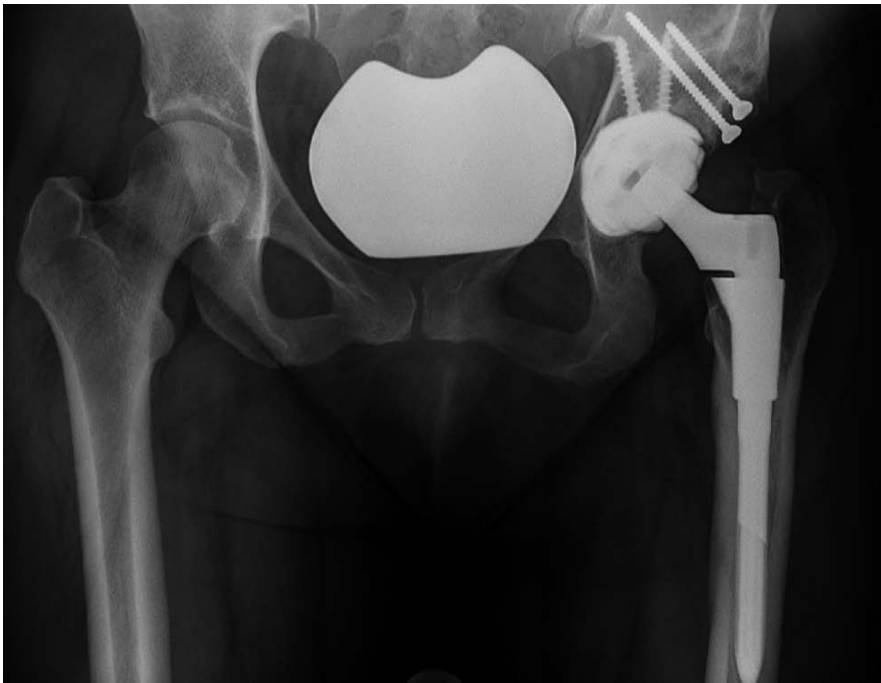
Postoperative radiographs after restoration of a Crowe grade III deformity. The anatomical hip center is restored with a femoral bone graft (Harris plastic).
